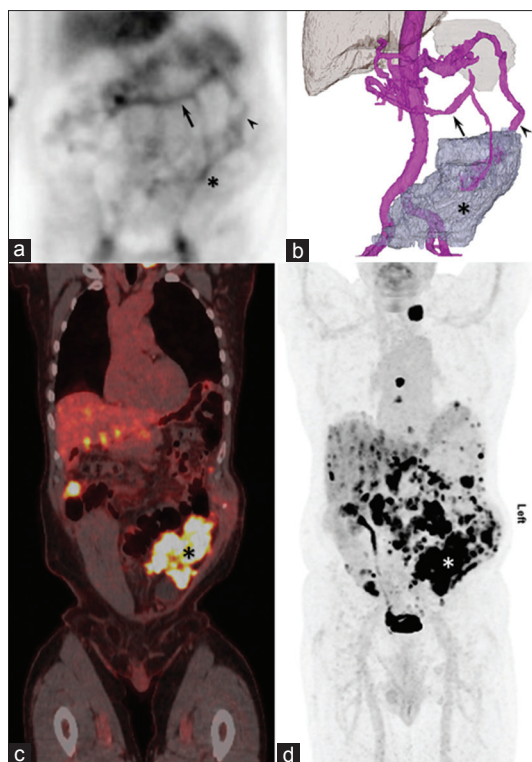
Anterior static scintigraphic image of ^{99m}Tc -radiolabeled autologous erythrocytes (a), along with a color-labeled three-dimensional reconstruction of the patient's recent computed tomography angiography of the abdomen and pelvis. Serpiginous-shaped activity on scintigraphy (b) corresponds to the enlarged gastroepiploic (arrows) and splenic (arrowheads) arteries supplying the omental carcinomatosis (asterisks). A single-slice coronal ^{18}F -fluorodeoxyglucose-positron emission tomography/computed tomography fusion image (c) and the maximal intensity projection from the same study (d) highlight the fluorodeoxyglucose avid metastatic burden in the left lower quadrant (asterisks)
